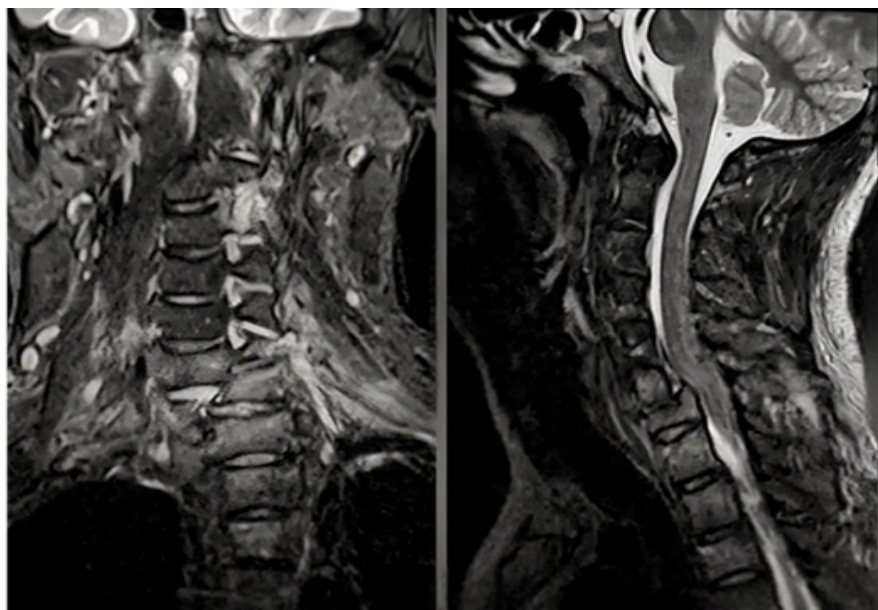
Pre-operative magnetic resonance imaging (MRI) cervical spine – coronal and sagittal T2-weighted images. Coronal (left) and sagittal (right) T2-weighted MRI images demonstrating severe cord contusion with intrinsic hyperintense signal change at C6–C7, traumatic disc disruption, posterior ligamentous complex injury, and significant canal compromise (Arbeitsgemeinschaft für Osteosynthesefragen modifiers M1 and M2).
